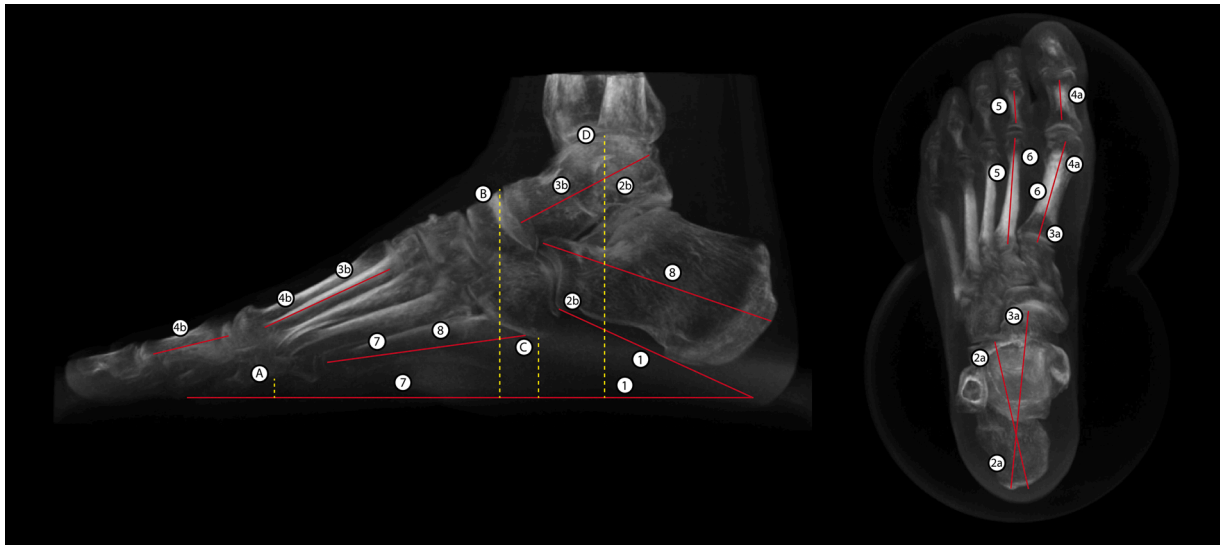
Digitally reconstructed radiographs of the foot in lateral view (left) and craniocaudal view (right), showing lines drawn by an investigator, which are used to perform 2D measurements (see text). Angles are defined by two lines with the same number. Heights are defined by the length of lines indicated by a letter.
